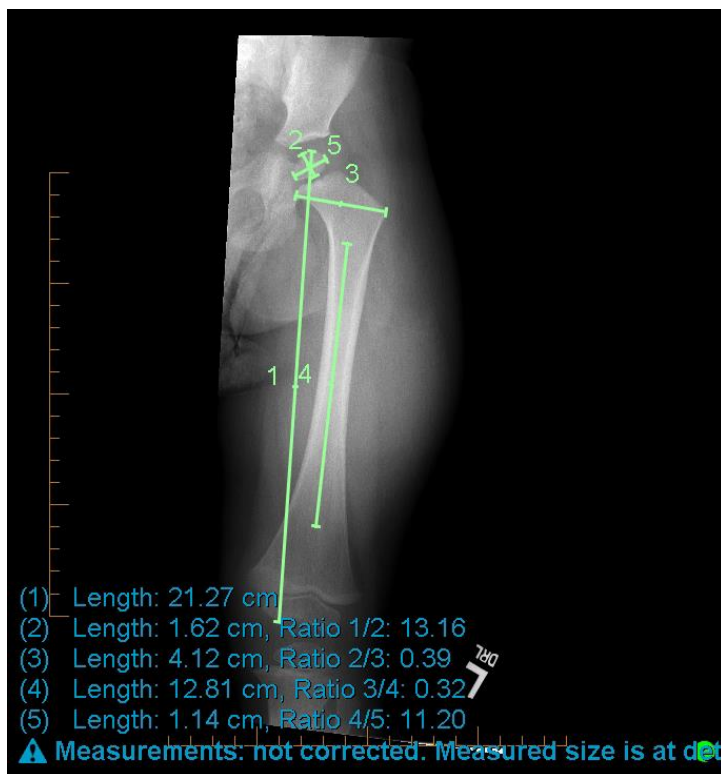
Radiograph with femoral measurements imposed over it
